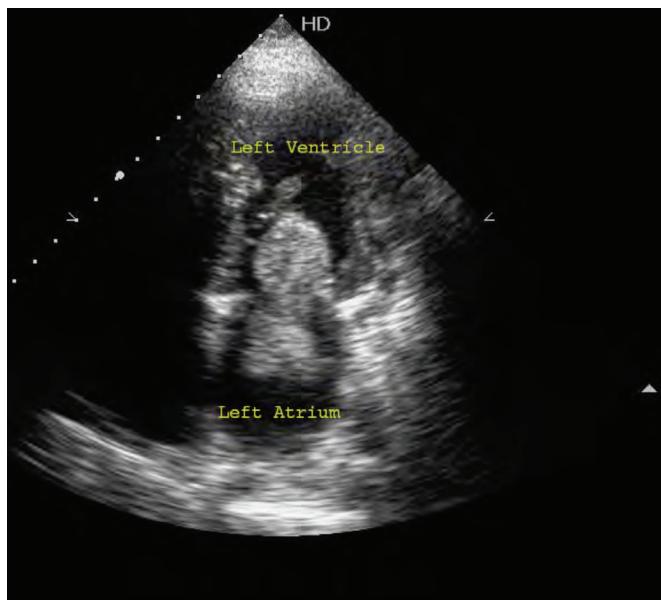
Echocardiographic image of the mobile mass in the left atrial cavity almost occluding the mitral inflow in the diastole.
